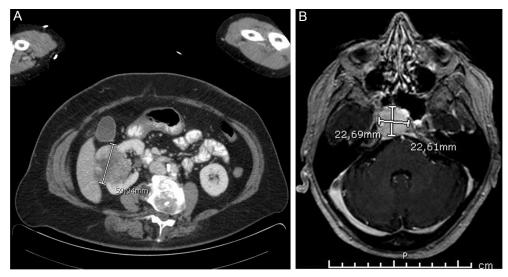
Imaging at diagnosis. A, Computed tomography of kidney cancer; B, magnetic resonance imaging of sellar metastase.
